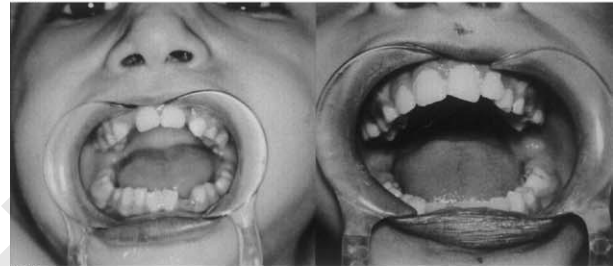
(A) Preoperative mouth opening of 16 year old girl (Case No: 8) with unilateral ankylosis (left) and mouth opening of the same patient, 6 years postoperatively (right). (B) Preoperative facial frontal view (left) and frontal view at completion of treatment (right). (C) Preoperative (left) and postoperative lateral view at completion of treatment (right). (D) Preoperative (left) and postoperative radiograph of fossa (right).
